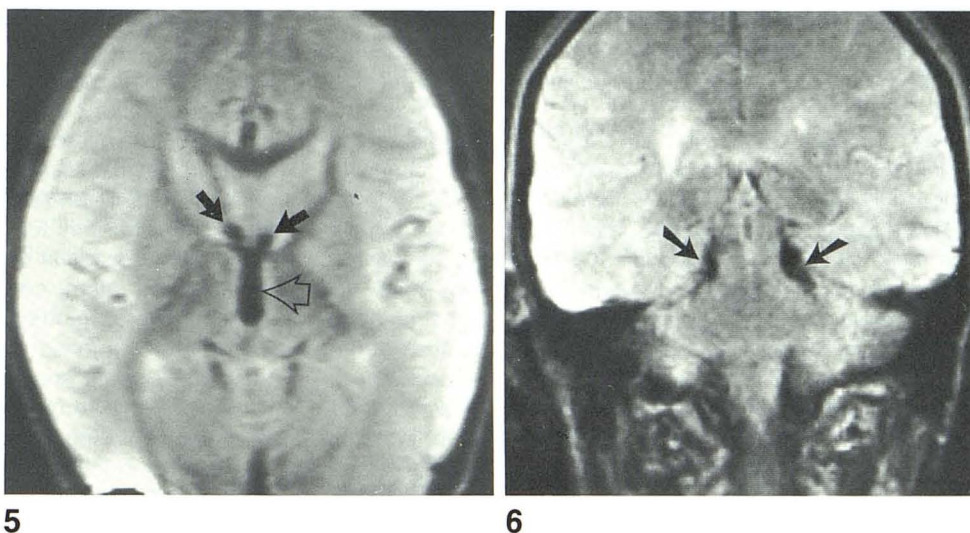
35-year-old woman with multiple sclerosis. T2-weighted (SE 2400/80) coronal scan through posterior brainstem is 5 mm thick. Prominent areas of decreased intensity in ambient cisterns (arrows) probably represent summation of CFVS and cerebral vasculature.
